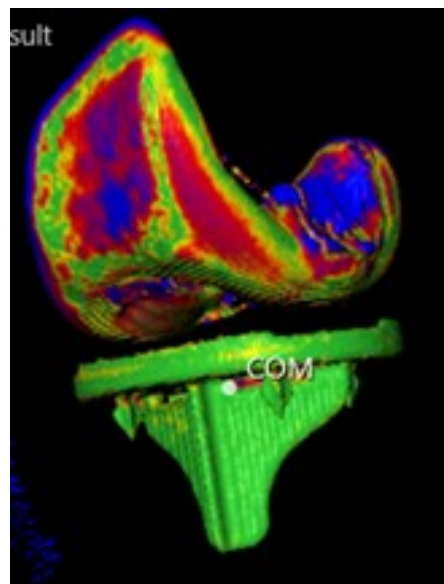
CT-RSA model of tibial and femoral implants in a T
